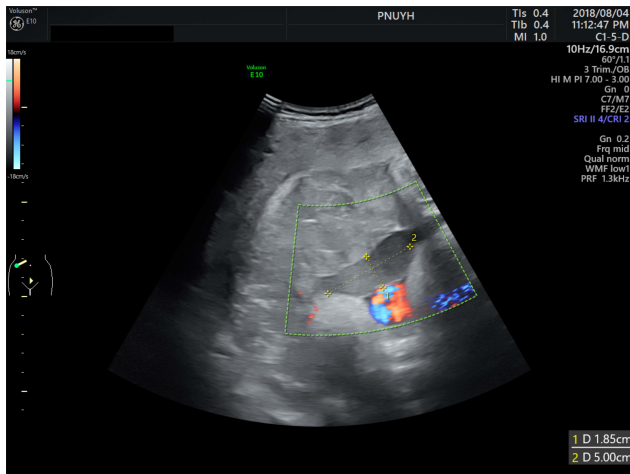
Ultrasound finding of subamniotic hemorrhage. Hemorrhage is shown as a low echogenic mass in between the placenta and the amnion. Color Doppler revealed negative findings within the hemorrhage.
